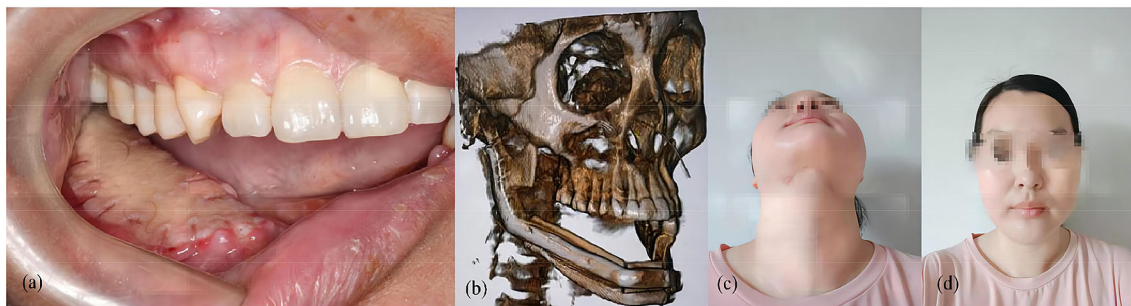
Postoperative information: a satisfactory soft tissue healing and blood supply 3 days after operation; b CBCT 3D image 3 days after operation; c facial profile was almost symmetrical 2 months after operation; d wound healed well 2 months after the operation
